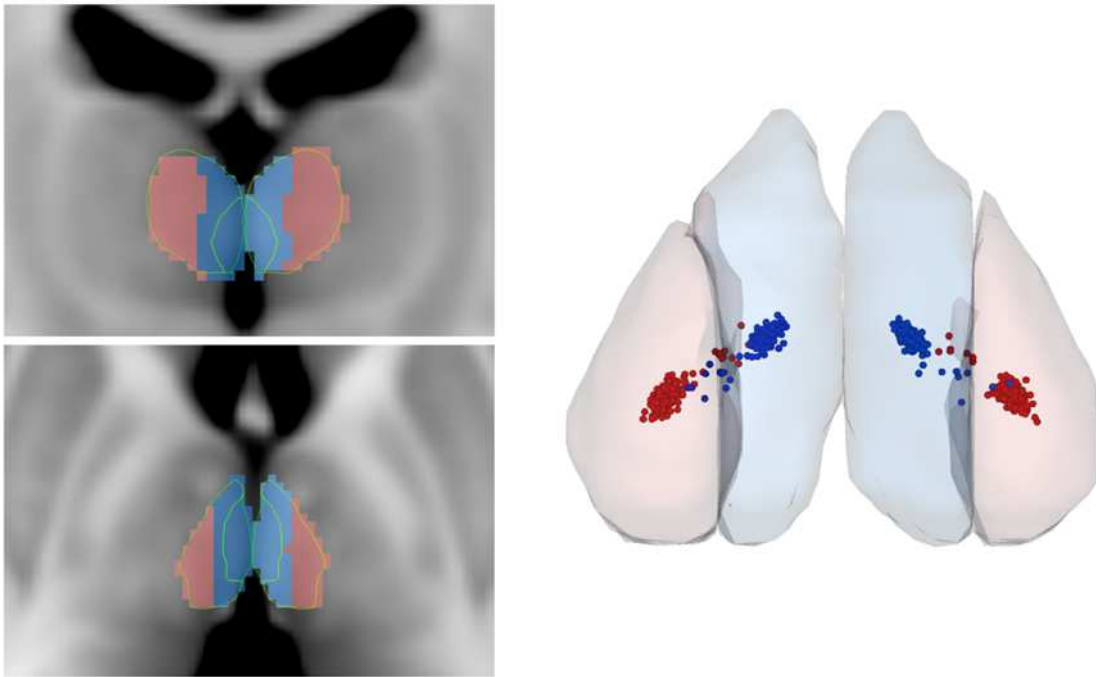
Visualization of the connectivity-based clusters of the human mediodorsal thalamic nucleus. Top and middle image: coronal and axial MRI images of the thalamus, with the connectivity-based clusters overlaid onto the MNI152 T1-weighted template. The outlines of the atlas-based MD_{mc} and MD_{pc+pl} borders are depicted [86]. Bottom image: 3D representation of the 50th percentile volumes of the medial (MD_{med}) and lateral (MD_{lat}) subdivisions, visualized with the center-of-gravity points of the segments for each subject ($n=155$).
